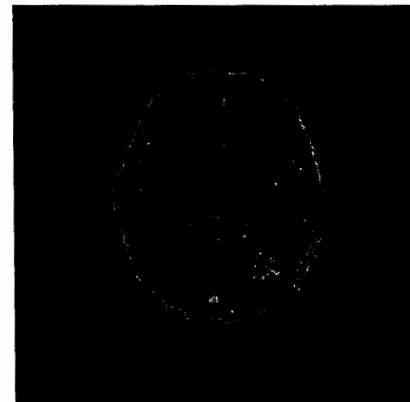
Fusion of PET and MR images of Brain by PCA
